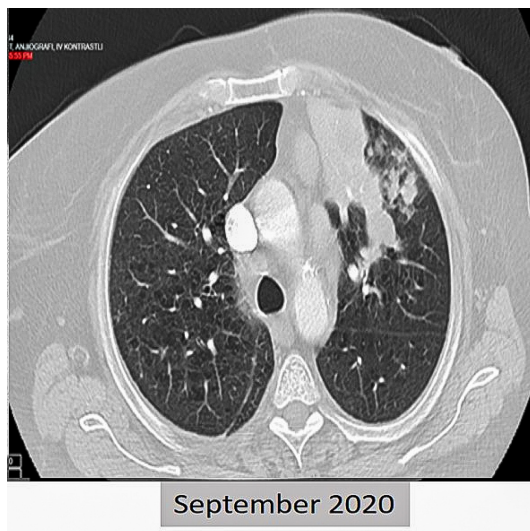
Positron emission tomography images and thorax computed tomography image at the time of diagnosis.
